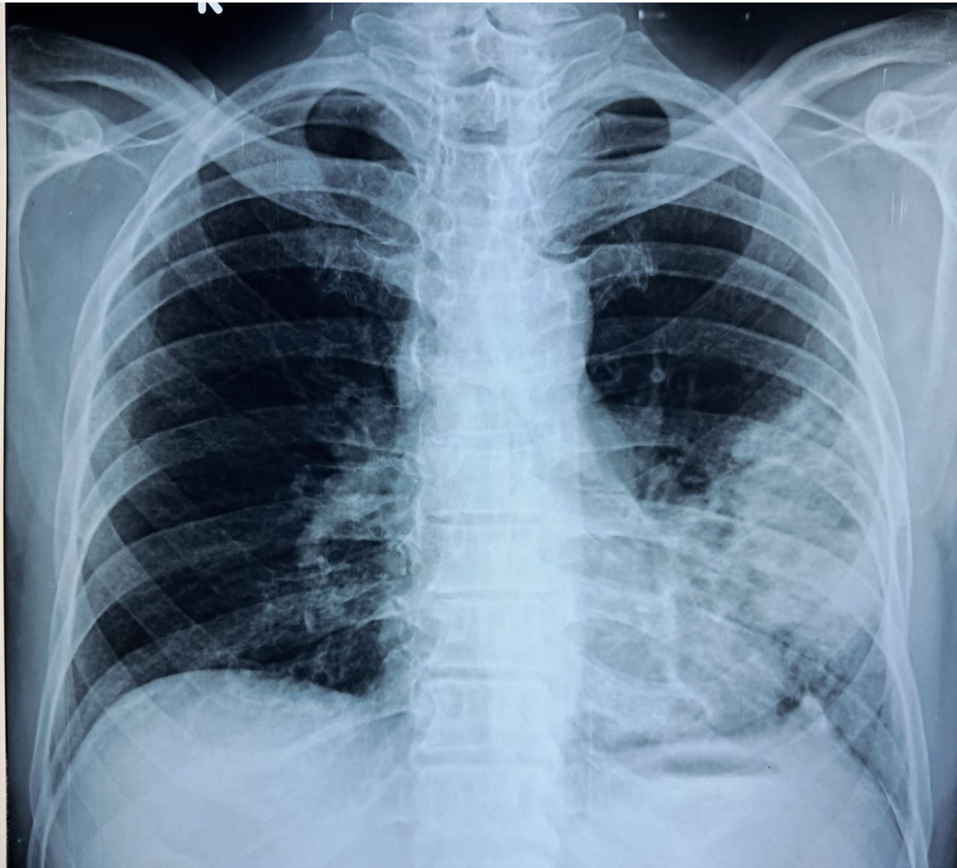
Chest x-ray P/A view showing consolidation at the left lower lung field.
